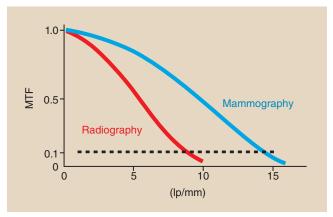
Screen-film mammography has a higher modulation transfer function (MTF) at low spatial frequencies and higher spatial frequencies than screen-film radiography.
